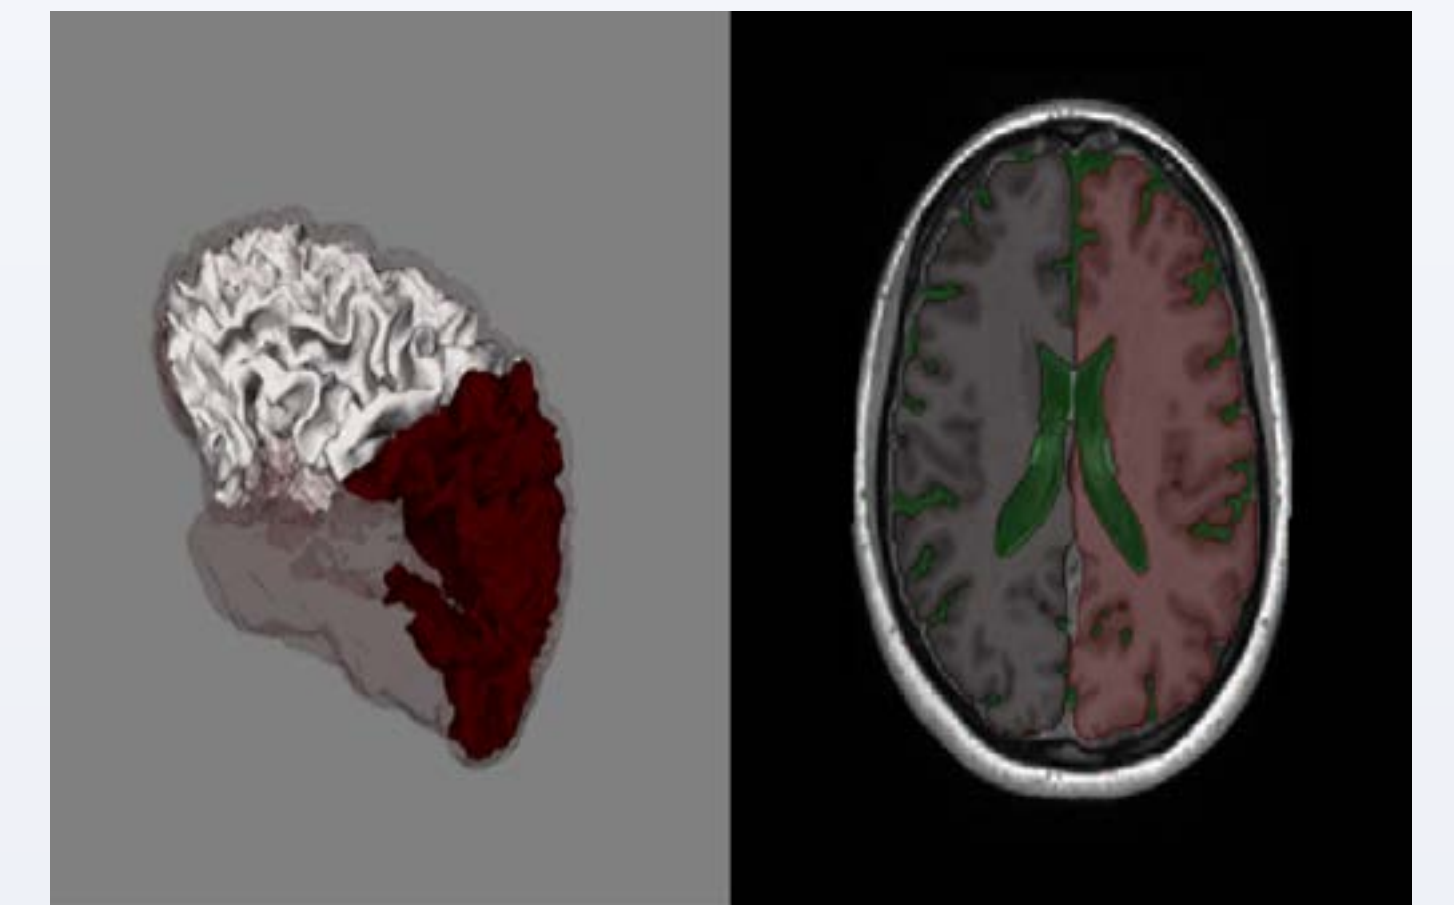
3D and VBM images of the grey matter of medical students after processing the MRI images.
